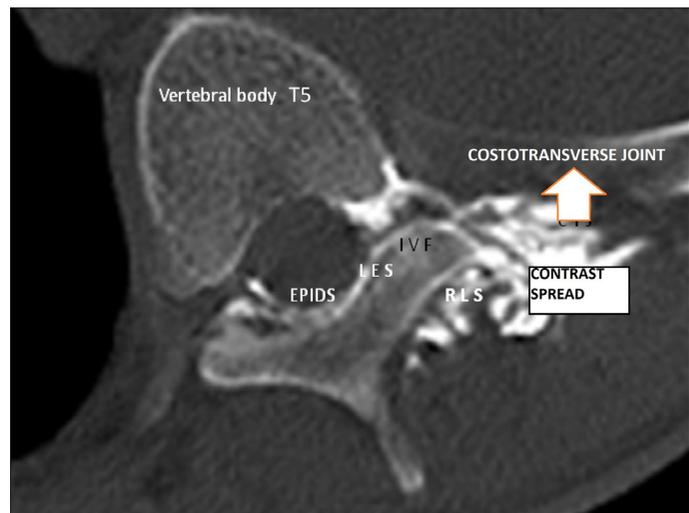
Computed tomography image shows radio-opaque contrast spread deep to the erector spinae muscle, a medial retrolaminar spread, paravertebral spread and posterior epidural spread through the intervertebral foramina space
